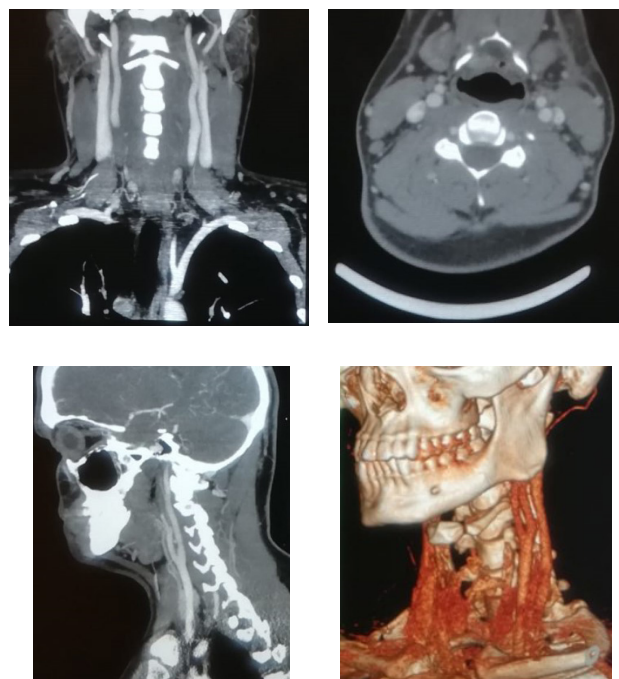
CT angiogram of the neck one year after the initial presentation in coronal, sagittal, and axial views, along with CT 3D reconstruction, showing complete resolution of the previously noted thrombus.
